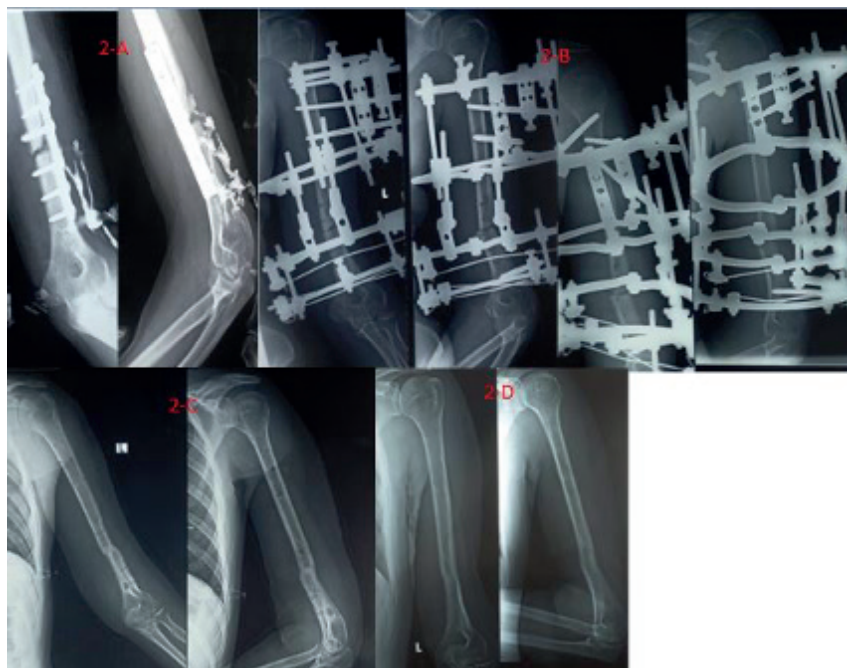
X-rays showing : A: pre-operative X-rays of infected non united fracture mid-shaft humerus fixed with a plate and screws. B : X-rays-after removal of internal fixation, sequestrectomy and Ilizarov application with acute compression. C & D : follow-up X-rays after Ilizarov removal.
